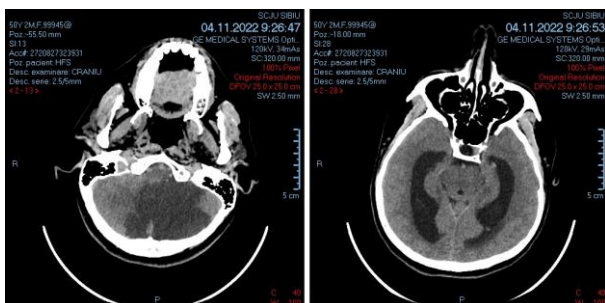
Native CT Head performed on 04.11.2022.
